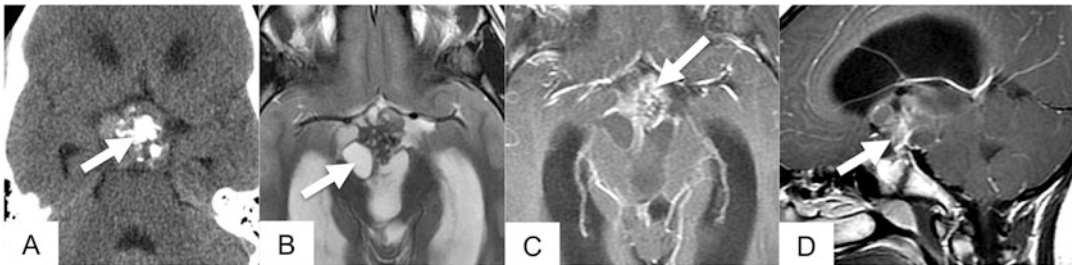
Craniopharyngioma. 7-year-old boy with a complex cystic suprasellar mass containing calcifications on CT (arrow; a), cysts (arrow, b), and irregular mural
